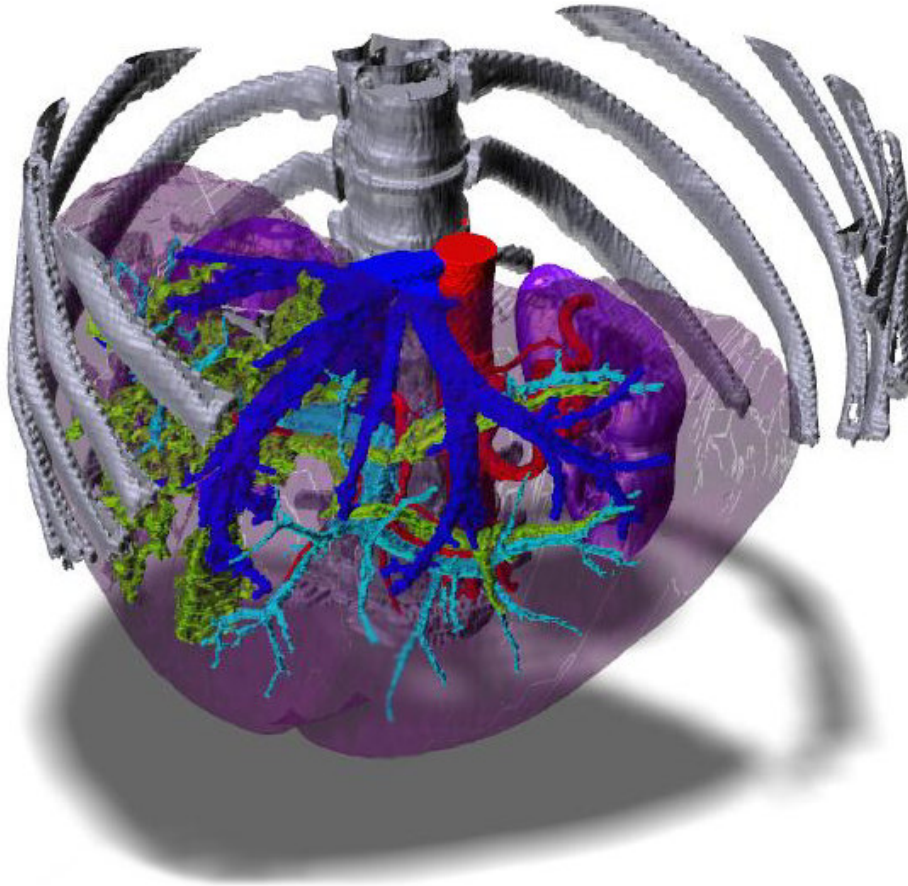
Patient specific 3D model generated from a CT dataset.
